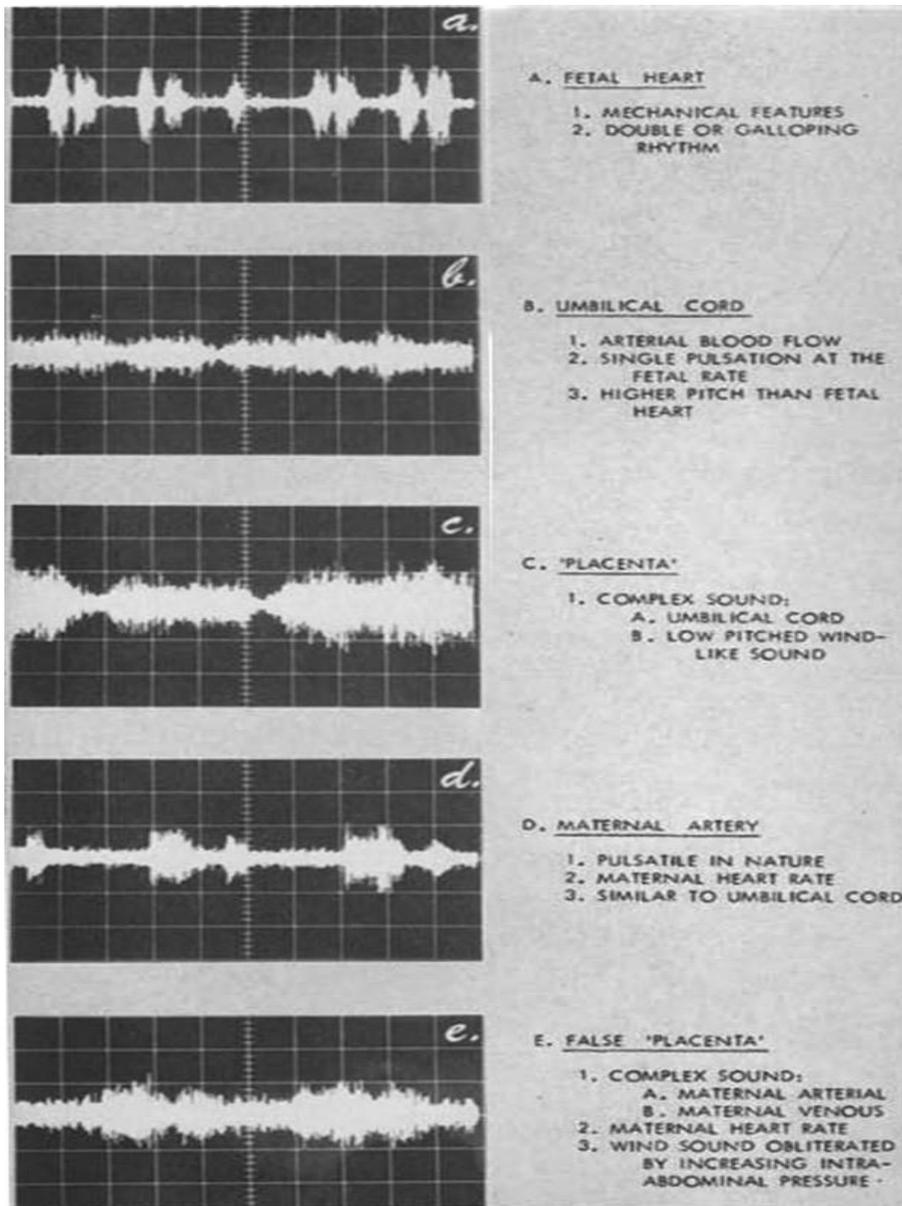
Continuous-wave Doppler from a 1967 publication shows different applications of ultrasonic pulse detector.
